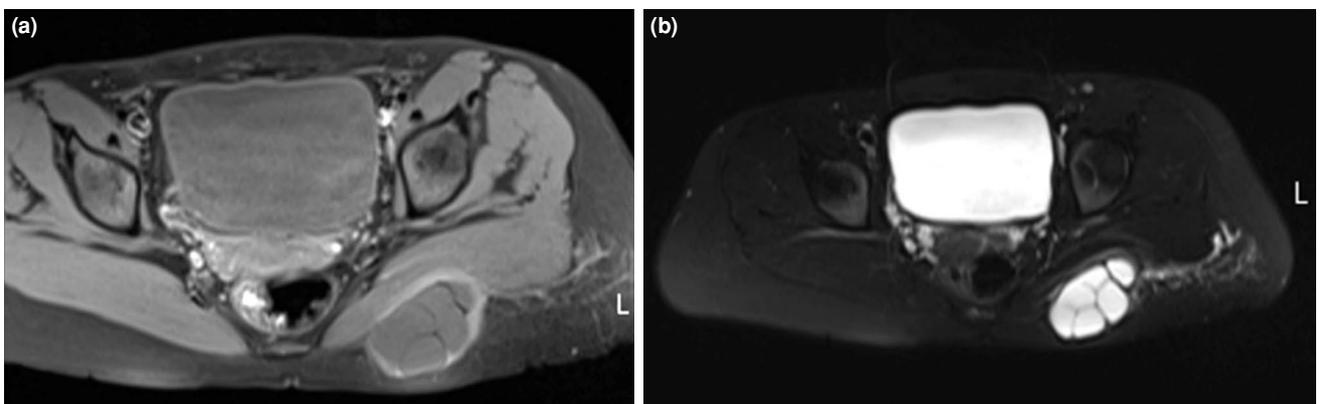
(a) Axial T1-weighted MRI before albendazole treatment showing multiple cysts in the gluteus maximus muscle and subcutaneous tissue. (b) Axial T2-weighted MRI before albendazole treatment showing daughter cysts with high signal intensity. MRI: Magnetic resonance imaging.
